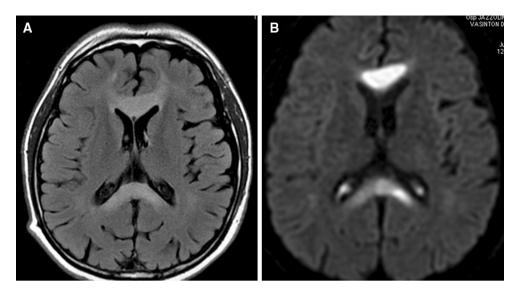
a Axial FLAIR imaging shows hyperintense changes in the genu and splenium of the corpus callosum. b Hyperintense signal on DWI, in the same areas
